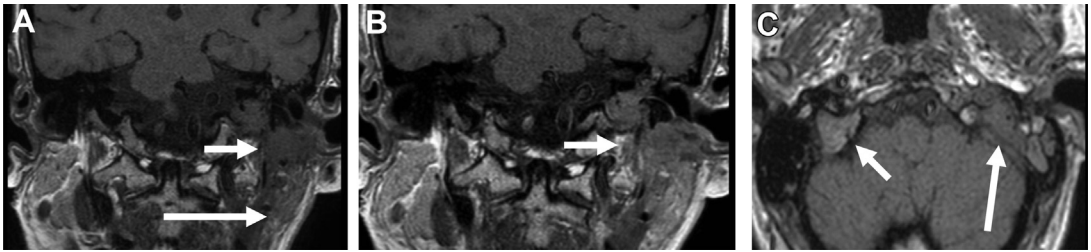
Progressive SCCA due to inadequate treatment planning. Precontrast and postcontrast MR imaging were performed in a patient with an unknown primary tumor with extensive left-sided adenopathy which extended to the mastoid tip. The patient was treated with radiation therapy alone; however, the patient presented with progressive left neck pain. (C) Coronal noncontrast enhanced MR imaging shows a large low signal (A) enhancing mass (B) extending to the left skull base (*small arrow*) which has a higher signal compared with the adjacent parotid gland (*long arrow*). Axial images show diffuse replacement (*long arrow*) of the skull base compared to the contralateral side. These findings are consistent with a progressive tumor. These images were correlated with the treatment plan and the superior extent of the radiation did not include the mastoid tip with the superior extent of the field being between the long and short arrows on image A.
